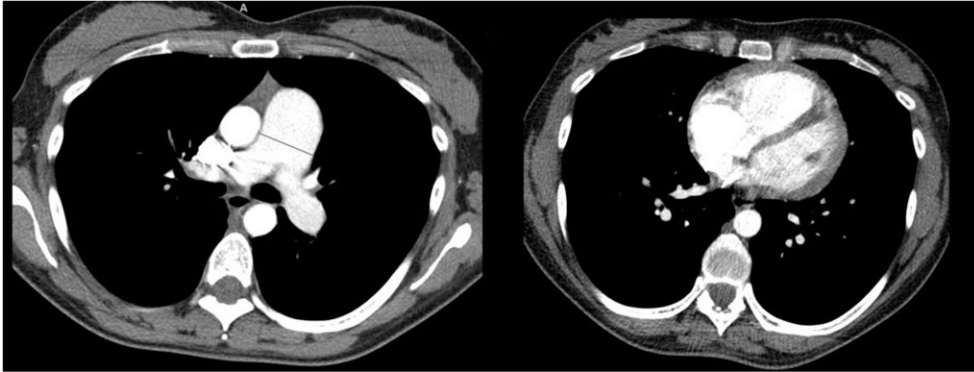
Left: Contrast enhanced computed tomography ruled out acute pulmonary embolism. The pulmonary trunk was dilated (37 mm, red line); right: atypical computed tomography four-chamber view showing enlargement of the right ventricle.
